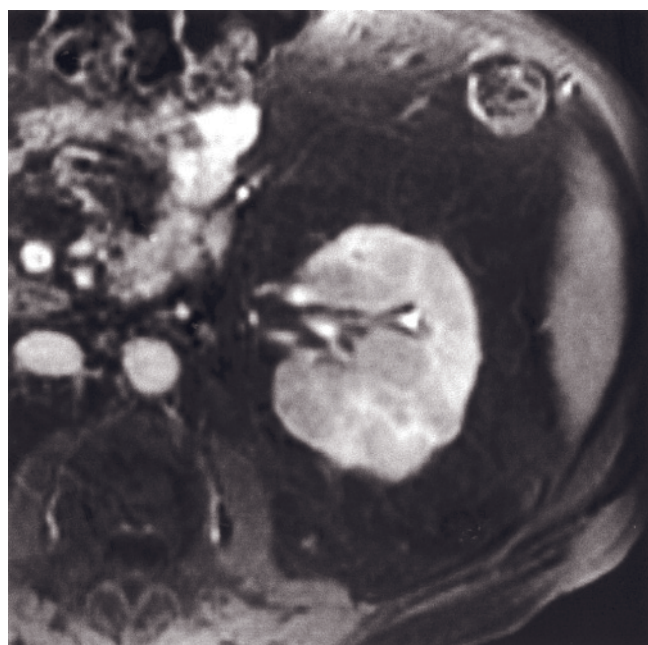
Malakoplakia. Coronal (a) and transverse (b) T2-weighted SS-ETSE and transverse T1-weighted precontrast (c) and 1-min postgadolinium (d) SGE images. The kidneys are enlarged, with an extensive multinodular appearance. High-signal septations are appreciated on the T2-weighted sequences (a, b), which enhance after gadolinium administration (d). T2-weighted
